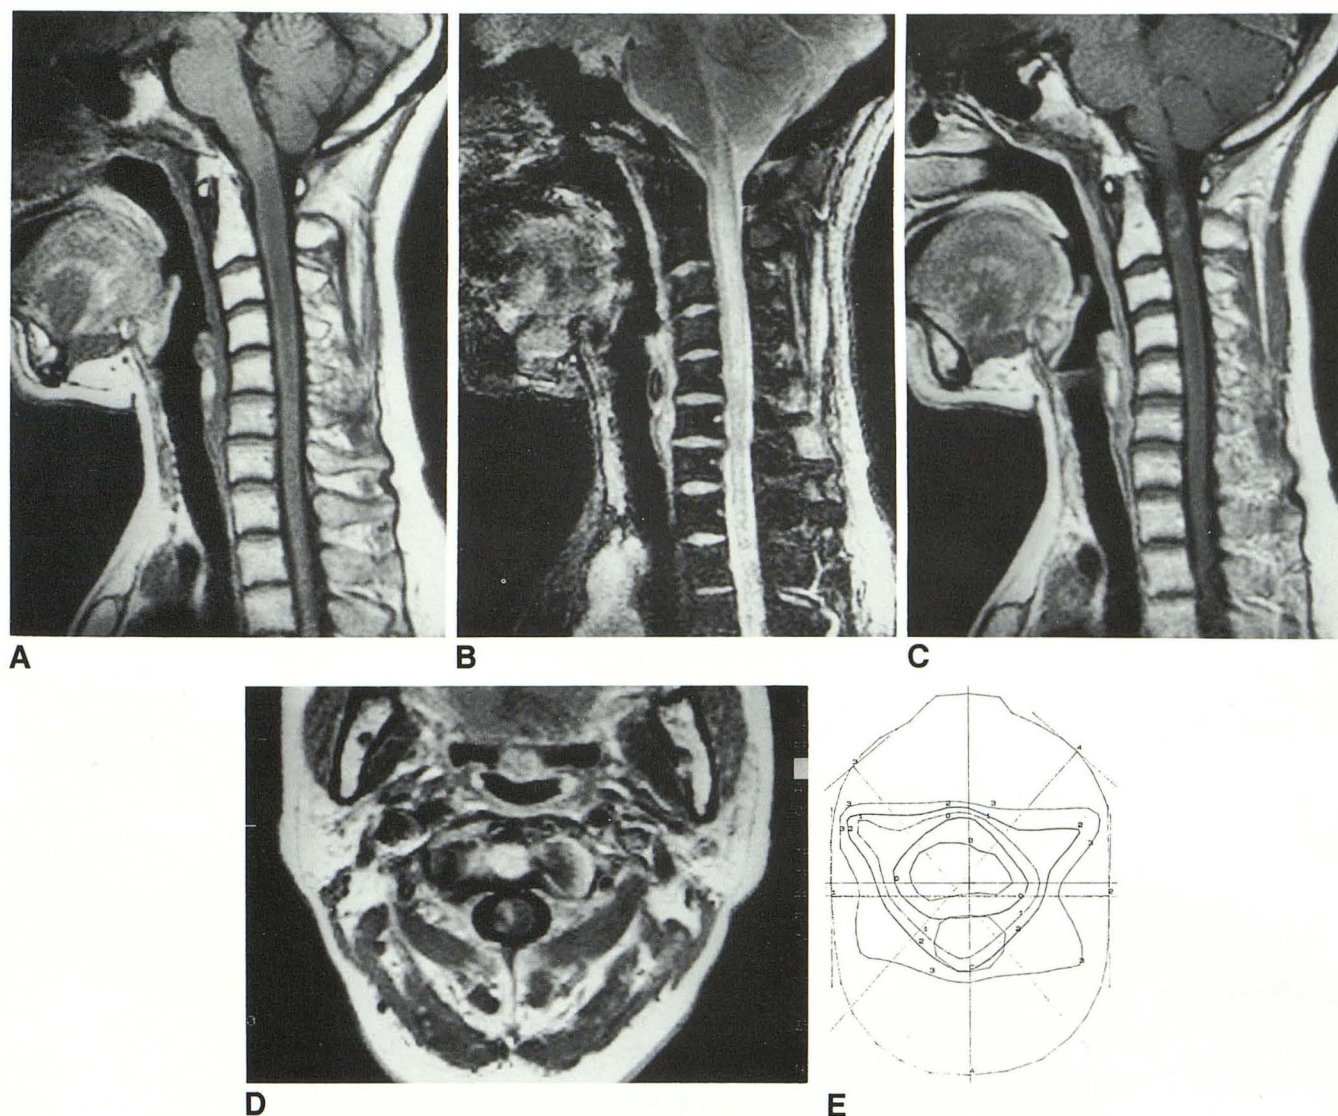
The first MR images of the cervical cord and isodose curve in case 6.
